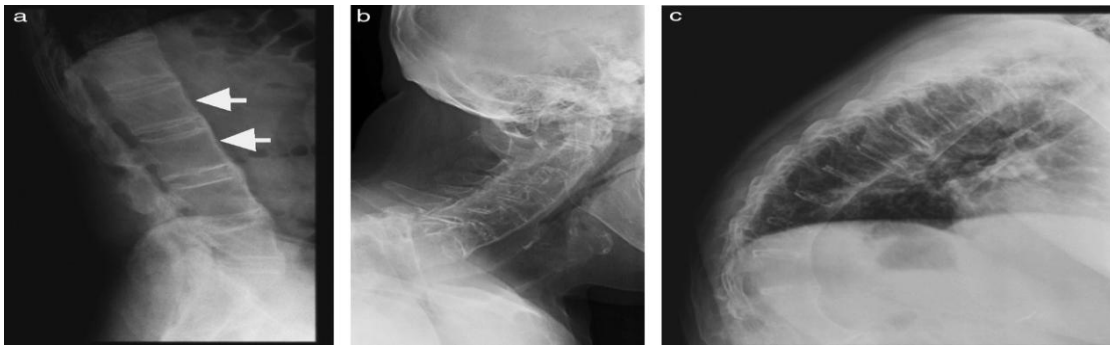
Lateral projections of spinal radiographs from the same patient. Left (a): quadrature of the vertebral bodies of the lumbar spine, with loss of its normal anterior concavity (arrows). On the right (b and c) the same phenomenon, determined by syndesmophytes.
